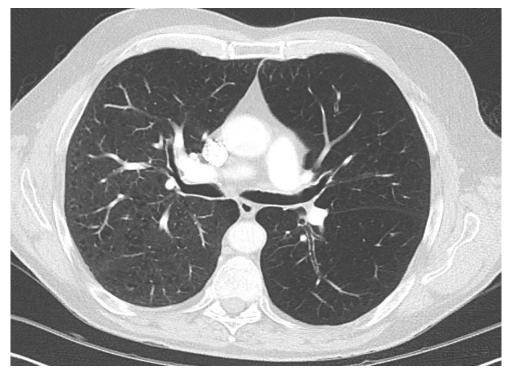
5: Excessive low attenuating emphysema in the lung in a low dose CT scan.
